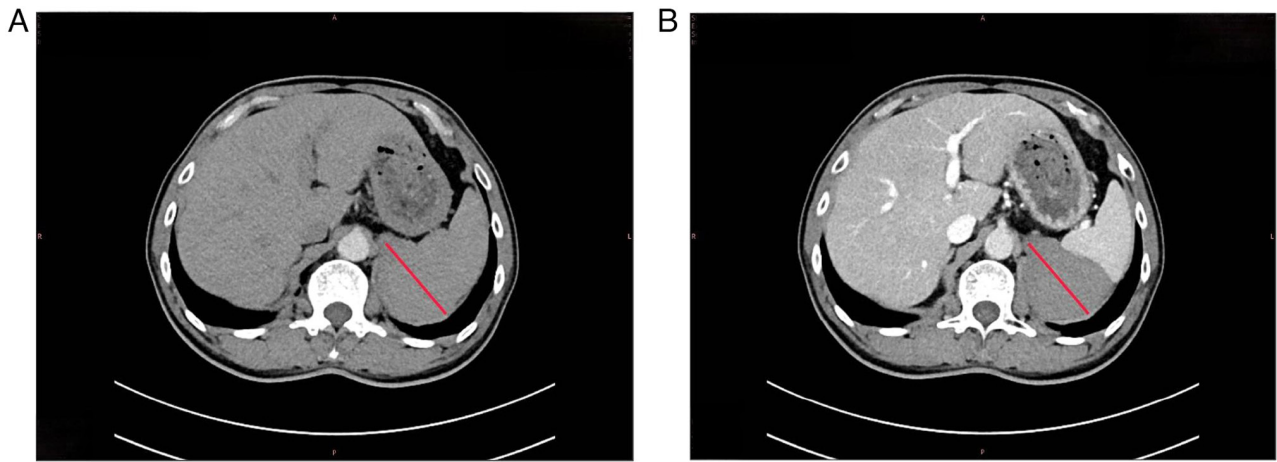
CT scan showing a thin-walled, sheet-like, soft tissue-like-density shadow in the left retroperitoneal region, with no enhancement on contrast scan (red lines indicate the diameter of the cyst). (A) Non-contrast CT scan. (B) Contrast-enhanced transverse CT scan. CT, computed tomography.
